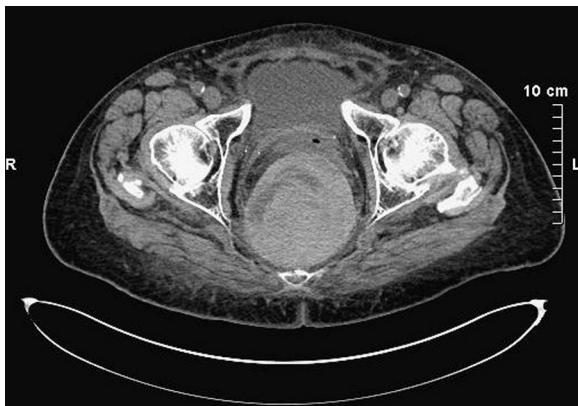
CT-scan showing a hematoma measuring 10 × 9.4 cm in the presacral space.
